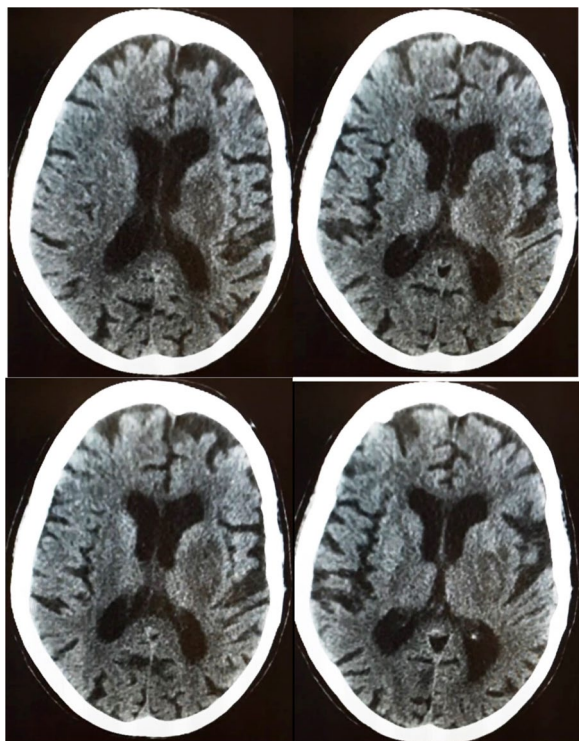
Third CT Findings (done within 72 h from complaint starting): showing a hypodense area involving the left ganglionic region coping with acute infarction
